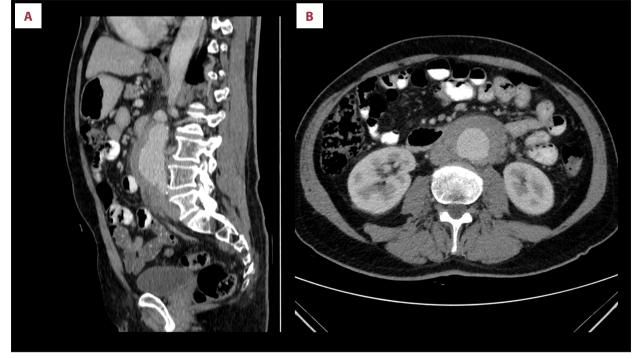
(A) Sagittal and (B) axial computed tomography images showing aortic aneurysmal dilatation involving the infrarenal portion of the abdominal aorta associated with a mantle of periaortic soft tissue thickening.
